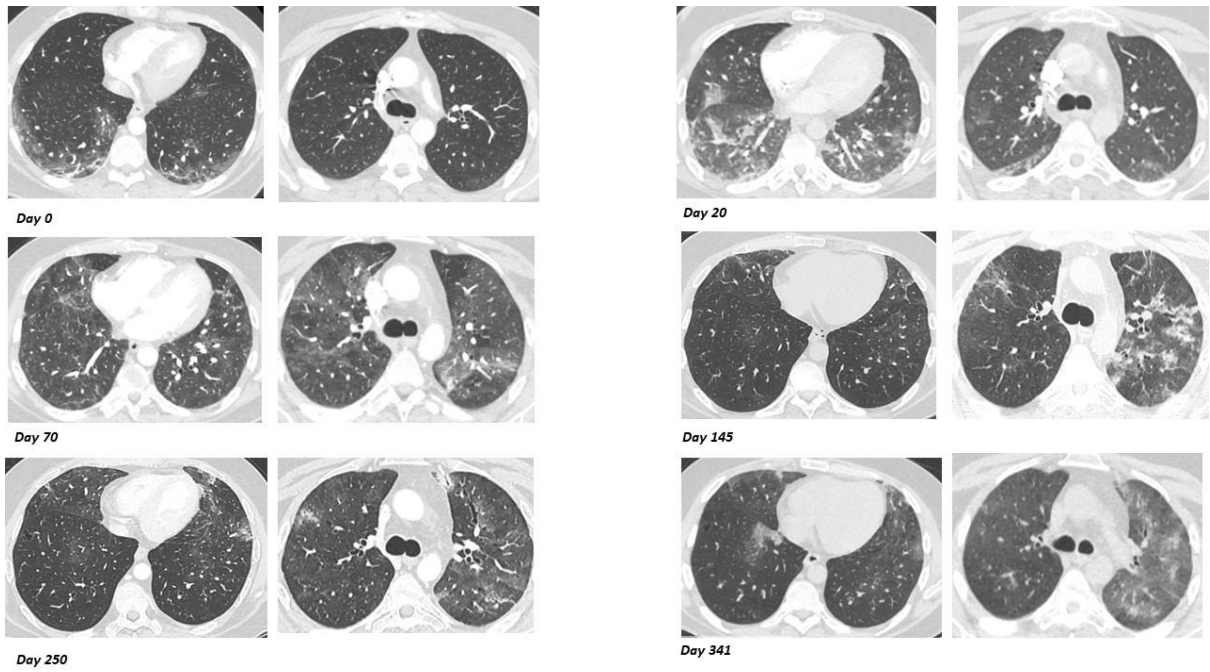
Figure in supplementary data: Chest computed tomography on day 0, 20, 70, 145, 250 and 341 showed multiple bilateral and peripheral ground-glass opacities with sub pleural alveolar condensation
